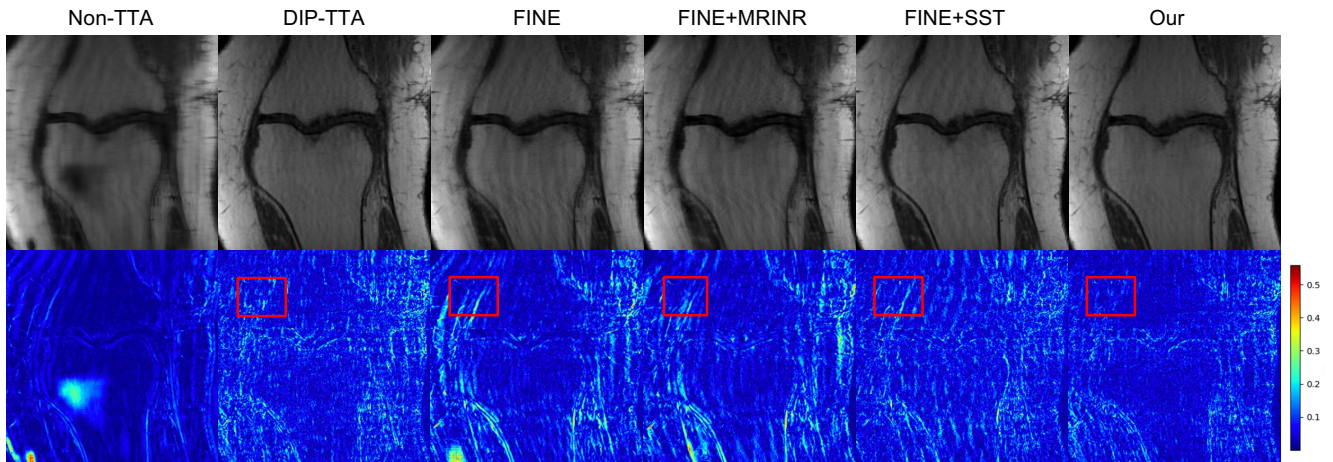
Comparison of different frameworks in Unet under acceleration shift (2X to 4X) using the FINE method. The first row shows reconstructed MRI images, while the second row presents residual maps between reconstructions and full-sampled MRI.
